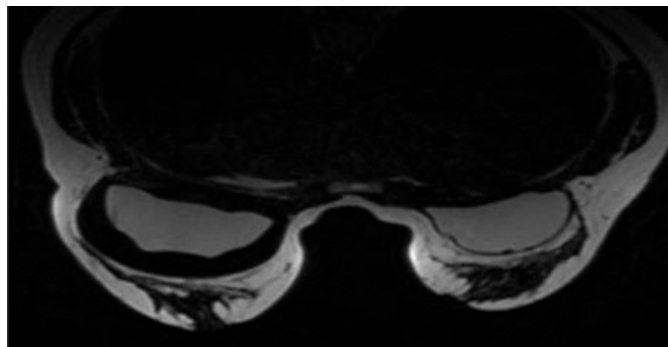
Breast MRI: Bilateral silicone breast implant with pericapsular seroma and capsular enhancement on the left.
